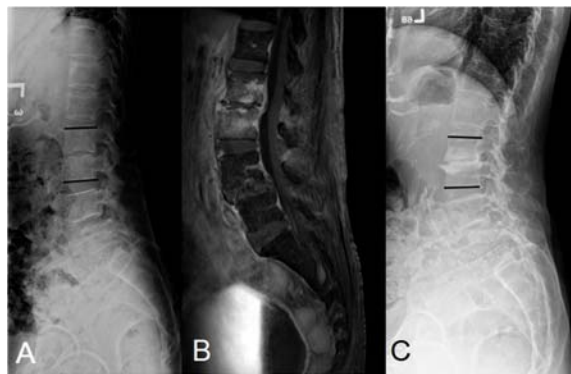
A 71-year-old woman presented with severe back pain without neurological deficit for 2 weeks. Her initial film (A) shows segmental lordosis of 10 degrees at L2 to 3. MRI (B) shows osteomyelitis at L3 body with right psoas abscess. Her culture was positive for MSSA, and she was treated with IV antibiotics. At the 2-year follow-up, no spinal deformity was observed at this segment. Film (C) shows marginal osteophyte at L2 to 3 with autofusion, and L2-3 lordosis of 6 degrees.
